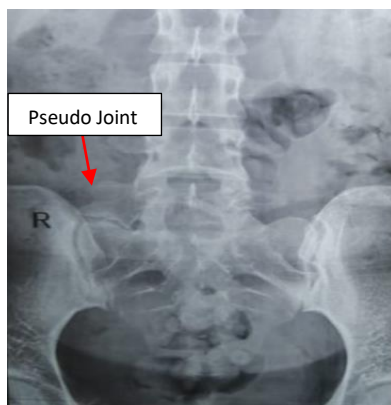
X-ray lumbosacral spine showing pseudo joint
